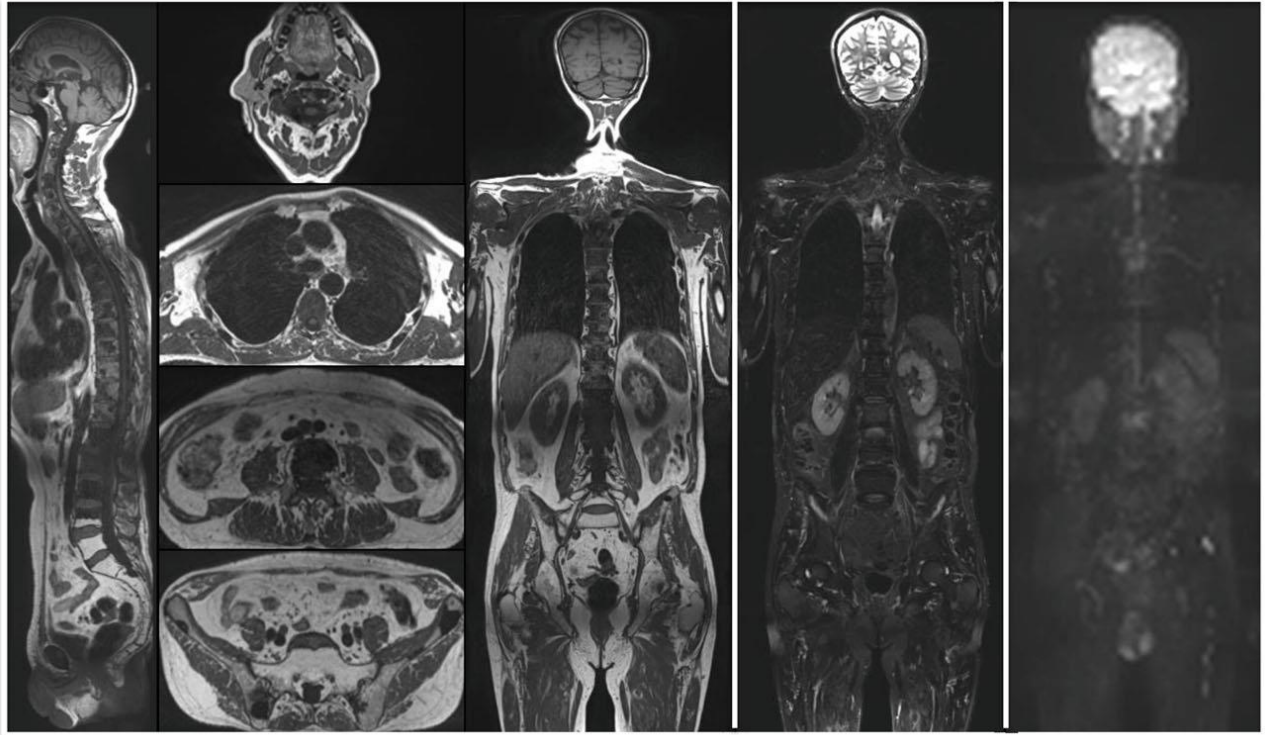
Whole-body MR images in a 69-year-old man with diffuse metastatic bone disease and signs of progression during antiandrogenic therapy. MR protocol corresponding whole-body 3D T1-weighted, STIR (short-tau inversion recovery) and diffusion-weighted images. Total scan time 54 min. a 3D coronal T1-weighted images with reconstructed sagittal and axial planes showing bone metastases as multiple hypointense foci involving vertebrae, ribs, hip, sternum and femurs. Early progression of disease is represented by the appearance of low signal intensity tissue adjacent to some of these foci (e.g. L2 and right iliac bone). b Corresponding STIR images confirm the predominantly osteosclerotic nature of the metastases which appear mostly hypointense; early progression of metastatic involvement is represented by the appearance of moderately high signal intensity bone changes. c DW images with 3D maximum intensity projection reconstruction identify early progression of disease as appearance of hyperintense bone foci representing tissue with restricted diffusion due to high cellularity. The remaining bone metastases are not clearly seen on the DW images, representing false-negative findings due to advanced sclerotic changes inside the lesions
